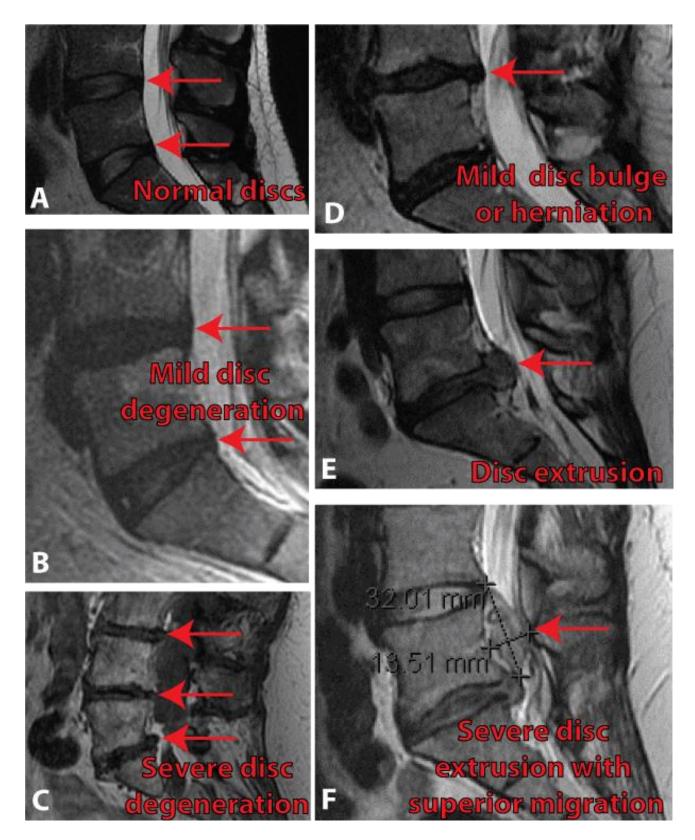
MRI showing disc degeneration & disc herniation
